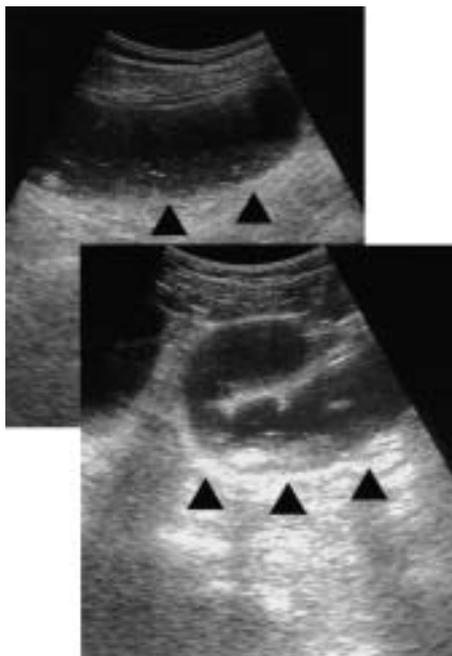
Ultrasonography of strangulated ileus
